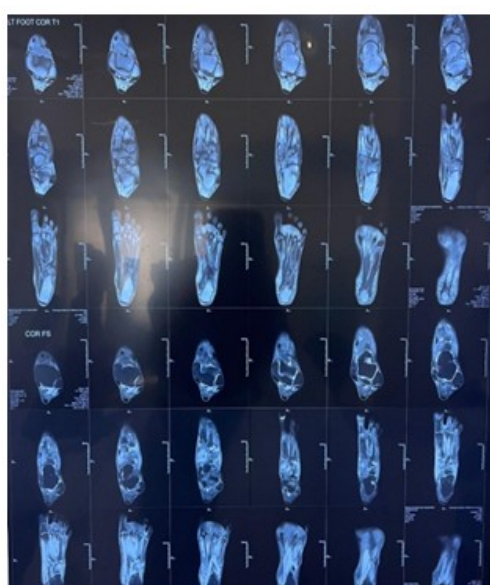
A,B,C MRI images of the left foot in transverse, sagittal, and coronal planes reveal marrow edema, cortical destruction, and bony lysis involving the tarsal and metatarsal bones. Soft tissue swelling, abscess formation, and a possible sinus tract extending to the dorsal surface are evident, consistent with tuberculous osteomyelitis.
